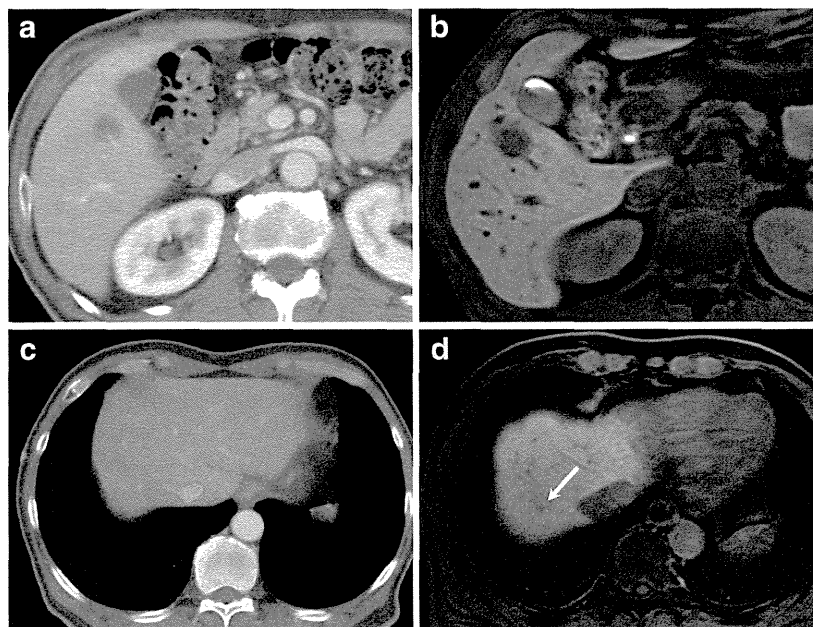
Surgically-proved liver metastases from colon cancer in a 67-year-old man. A 16 mm diameter liver metastasis could be detected in segment 5 on both portal phase of CE-CT images (a) and hepatocyte-phase of gadoxetic acid-enhanced T1-weighted GRE images (b). On hepatocyte-phase (d) of gadoxetic acid-enhanced T1-weighted GRE images, additional sub-centimetre metastasis was identified in segment 7
